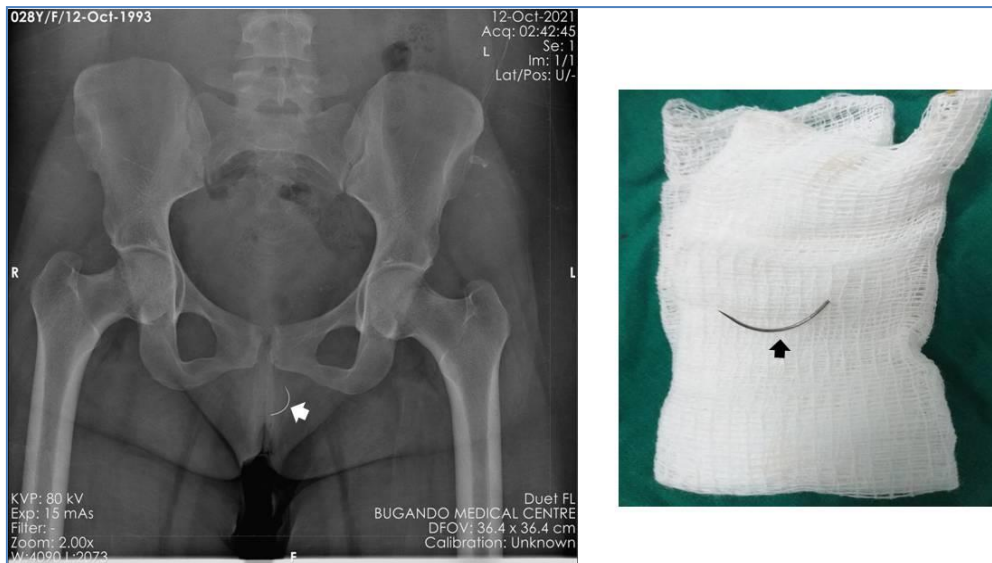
On the left, a Pelvic x-ray of Case 1 demonstrating an opaque curvilinear object (short solid white arrow) within the left paramidline perineal soft tissues in keeping with a retained needle. On the right, post procedural image of the retrieved needle (short solid black arrow).
